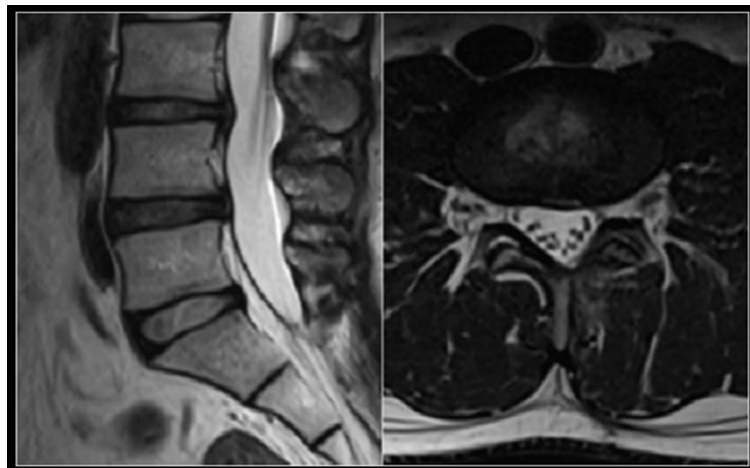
Follow-up magnetic resonance imaging at 6 months demonstrating no evidence of recurrence with preservation of the posterior soft-tissue structures.
